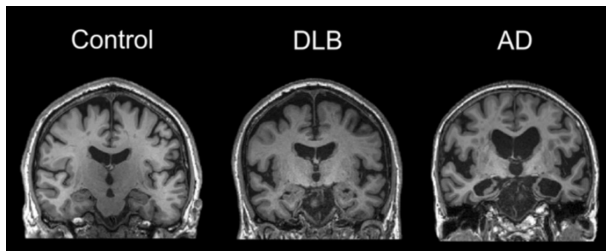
MRI brain scans of Control, DLB, and AD patients. The Control MRI shows a healthy brain with normal hippocampal and medial temporal lobe size, while the AD MRI displays clear atrophy, especially in the medial temporal regions. DLB shows intermediate patterns between Control and AD. Adapted from Chouliaras & O'Brien (2023)
